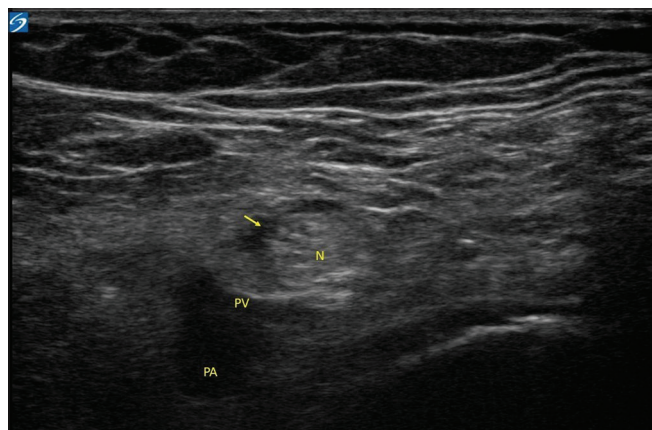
Ultrasound image of the popliteal sciatic nerve with pre-injected saline. N, sciatic nerve; PA, popliteal artery; PV, popliteal vein; arrow, pre-injected saline
